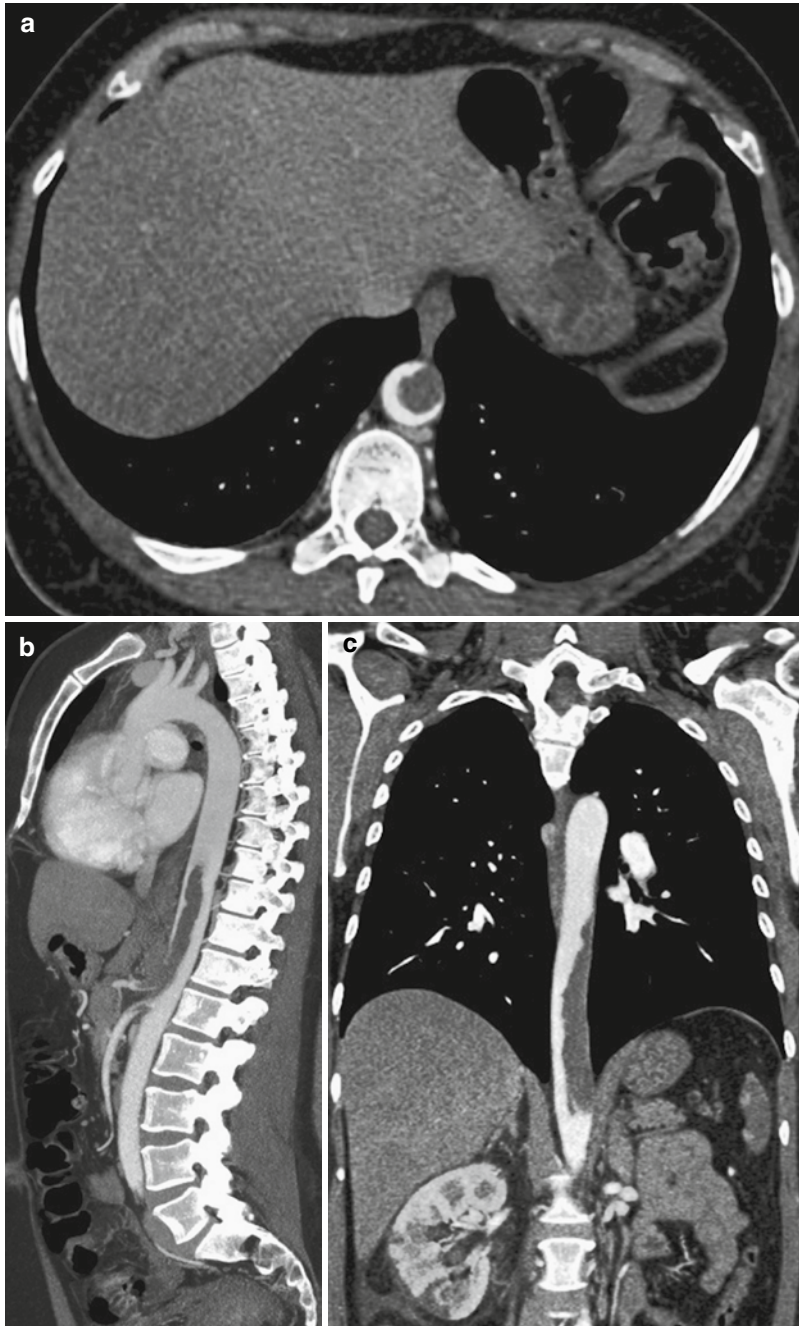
Axial CT image (a) demonstrates an endoluminal filling defect in the non-aneurysmatic descending aorta of a young woman. Sagittal (b) and coronal (c) reformatted images demonstrate the features of the sessile
